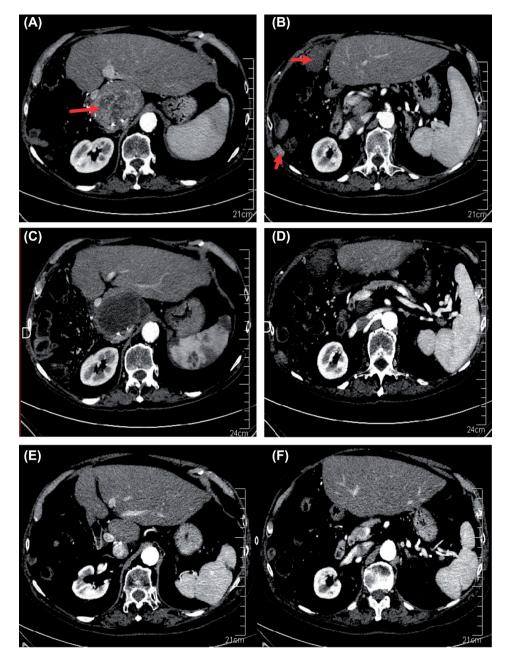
Patient 3. (A, B). In August 2007 CT scan evaluation showing a recurrence in the liver (A) and in the peritoneum (B). (C, D). A complete radiological response (mRECIST criteria) was observed in November 2007 after 3 months of sorafenib. (E, F). In October 2012, the patient was still alive without any lesion on the CT scan, 54 months after cessation of sorafenib.
